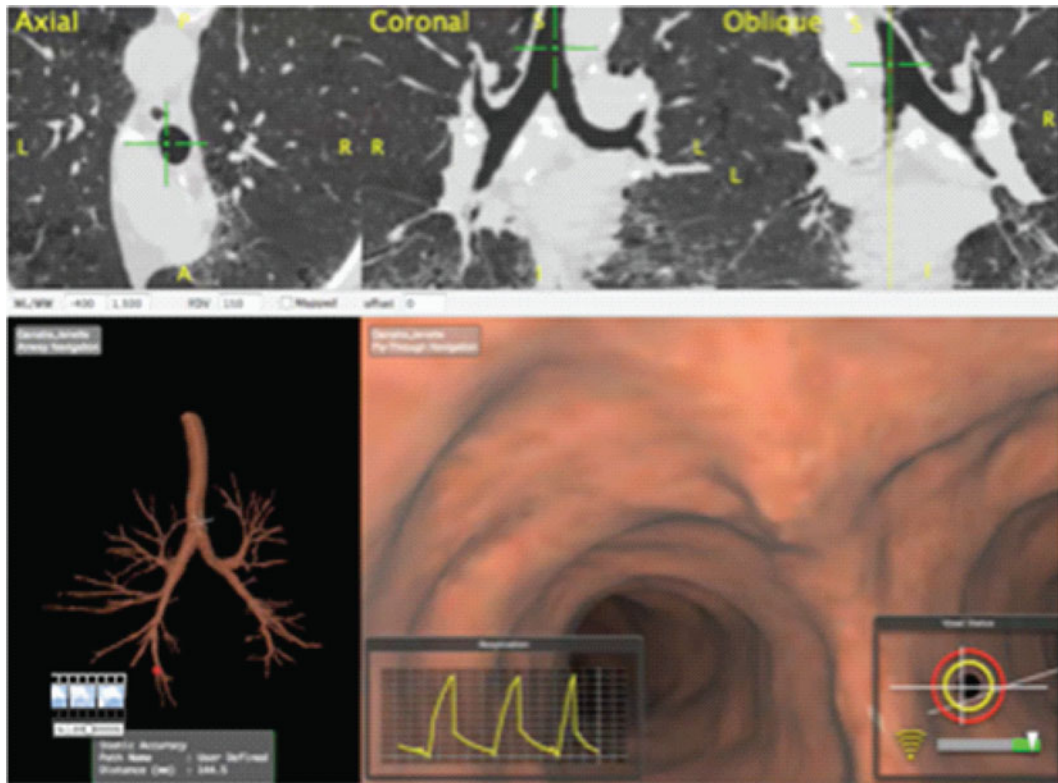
Display the 3-D tree and CT views during navigation
